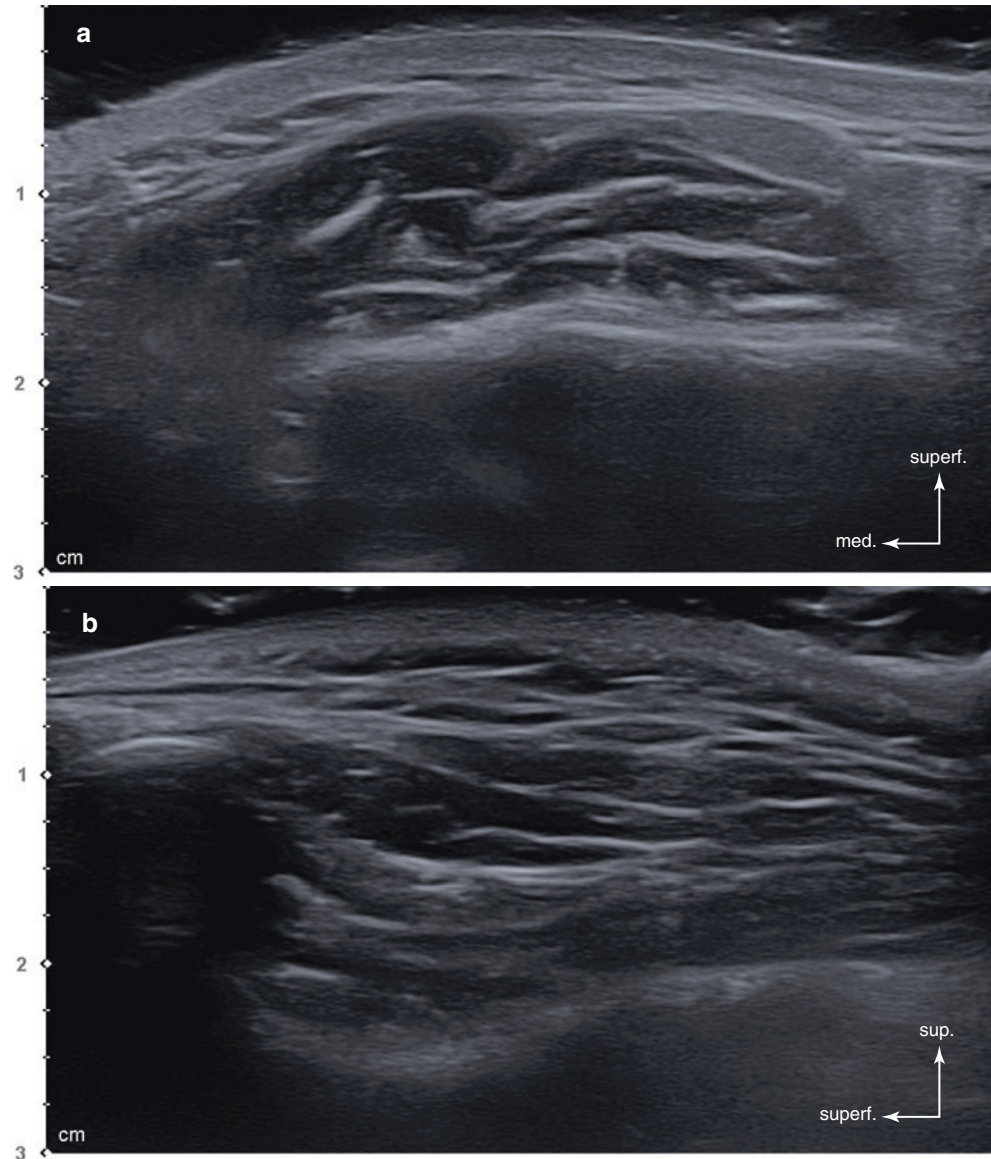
Ultrasonography of intramuscular tendinous structures. (a) Masseter muscle (transverse view, 15 MHz by linear transducer) and (b) temporalis muscle (coronal view, 15 MHz by linear transducer). (Published with kind permission of © Hee-Jin Kim 2020. All Rights Reserved)
